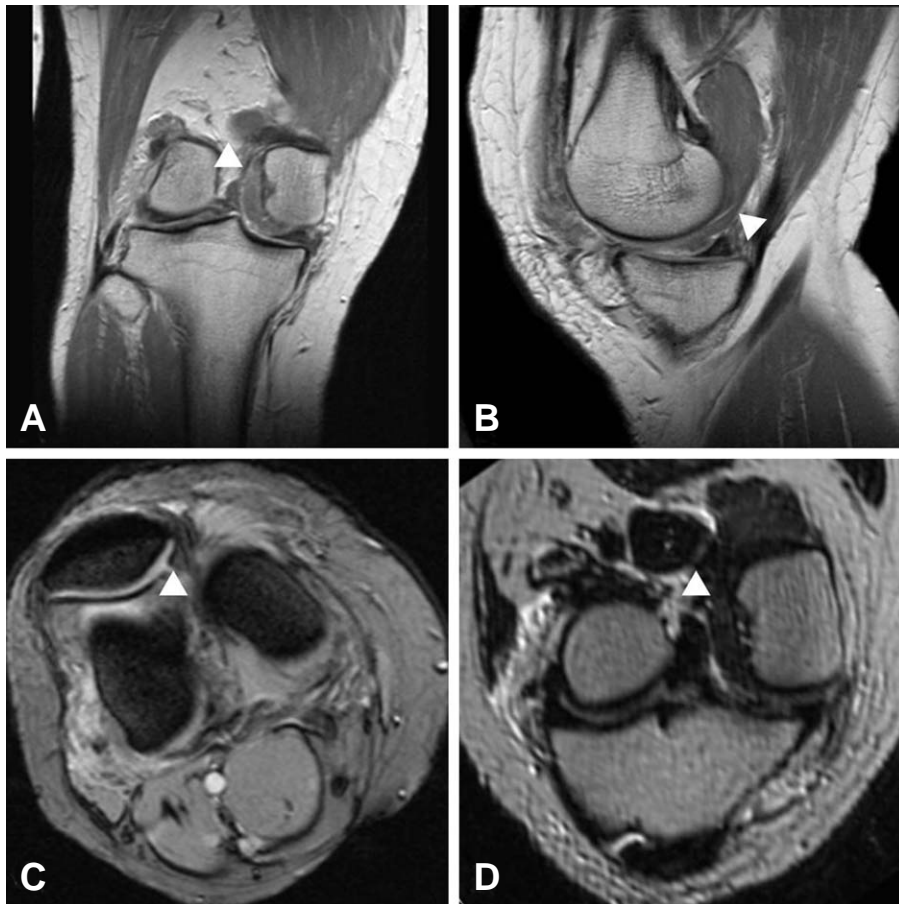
Pre-operative MRI. MRI showed incarcerated structures (vastus medialis muscle and fascia, white arrow head) with low to intermediate signal intensity in the intercondylar notch. (A) Coronal plane (B) Sagittal plane (C) Axial plane (D) Oblique coronal plane.
